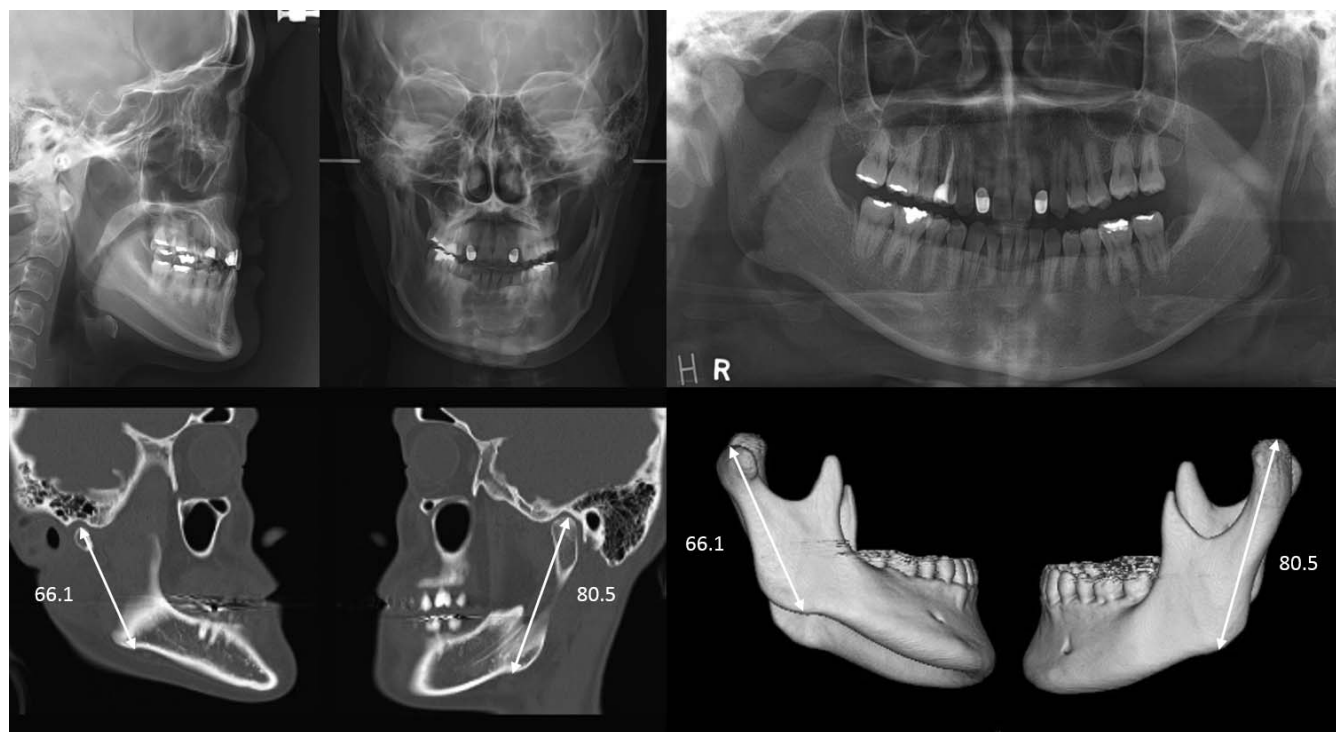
Lateral and posteroanterior cephalograms, panoramic radiograph, and three-dimensional computed tomography taken at the initial visit (age 29 years, 2 months).
